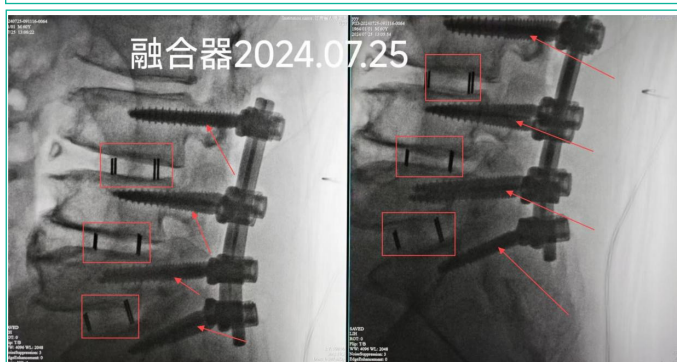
Intraoperative X-rays confirmed that the internal fixation devices were properly positioned, including the fusion construct, pedicle screws, and metal rods.
